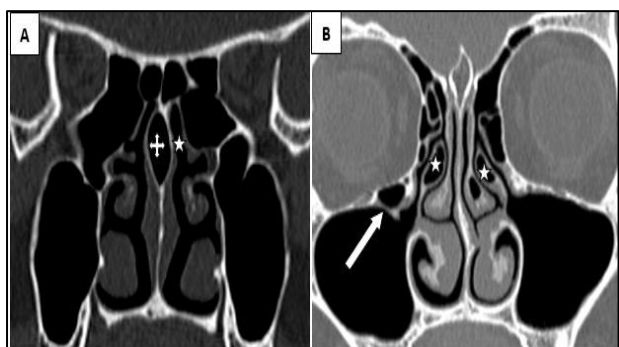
(A) Septal bullosa - Coronal CT shows pneumatization of postero-superior portion of the nasal septum (+) usually narrows the sphenoethmoidal recess (*). (B) Haller cell - right infra-orbital ethmoid air cell (←) usually compromise the maxillary ostium and narrows the adjacent infundibulum leading to maxillary sinusitis. Bilateral pneumatized uncinate processes (*).
